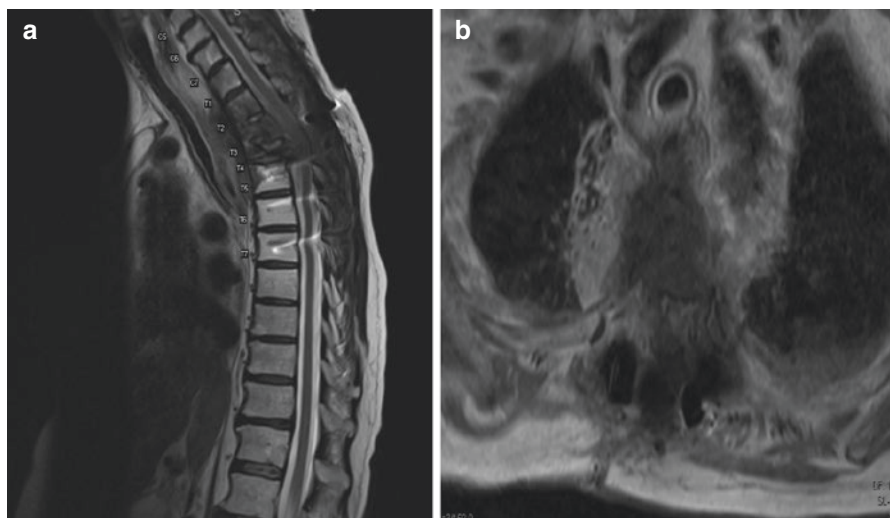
(a) T2 sagittal and (b) T1 post-contrast axial MRI of a 79-year-old female with metastatic squamous cell carcinoma of the lung who had previously underwent a C5–T7 posterior instrumented fusion with focal laminectomy over T3–T4. She subsequently presented with extension of ventral vertebral body tumor at T3–T4 with pull-out of previously placed hardware. She was taken back to the operating room for T3–T4 lateral extracavitary corpectomy and decompression with replacement of posterior pedicle screw instrumentation
